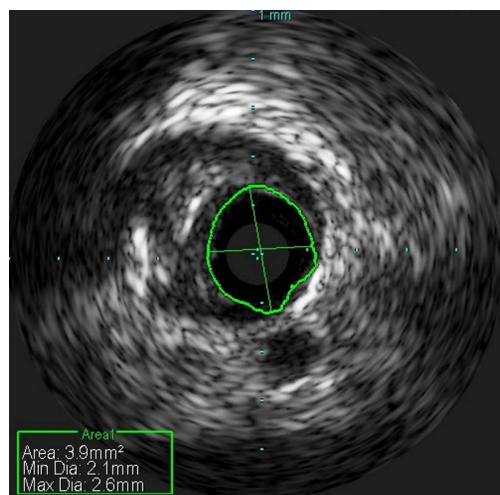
Intravascular ultrasound showing the area of the dissection
